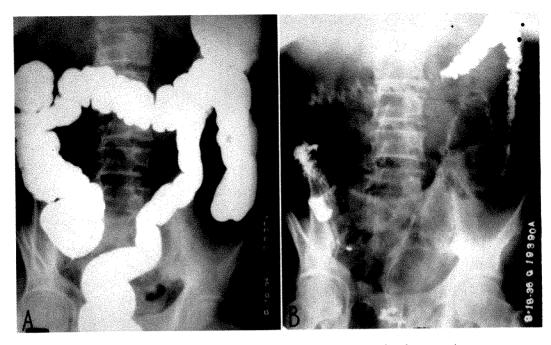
A, carcinoma of the large bowel, roentgen examination negative after barium enema; B, after evacuation of barium.
